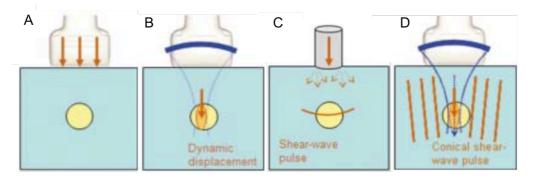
Scheme of ultrasound elastography methods. (A) Strain elastography; (B) acoustic radiation force impulse elastography; (C) transient elastography; (D) shear wave elastography. (Adapted from Bamber et al., 2013).
